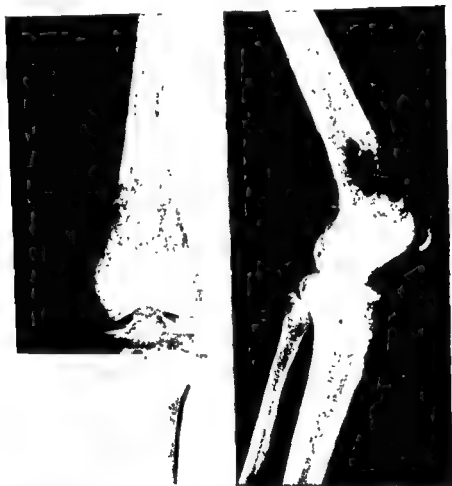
Roentgenogram of a benign chondroblastoma arising at the epiphyseal line and extending for some distance into the metaphysis. Note the multilocular structure of the chondromatous growth, the perforated bone shell, and the periosteal reaction suggesting a malignant character.
